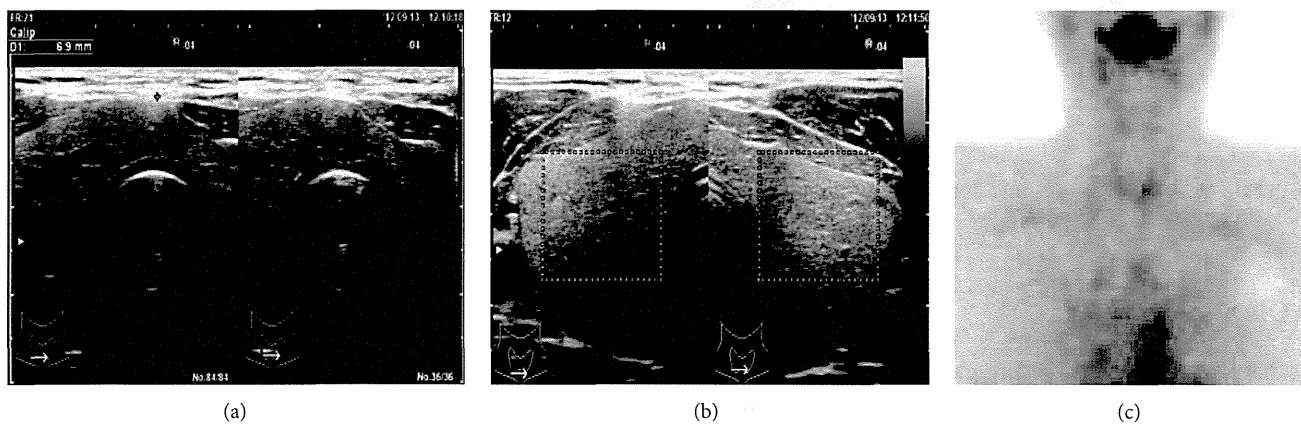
(a) Ultrasonic study of the thyroid revealing mild swelling with 6.9 mm isthmus diameter. (b) Doppler flow study of the thyroid gland revealing no blood flow increase. (c) Thyroid ^{99m}Tc scintigraphy revealing no uptake.
